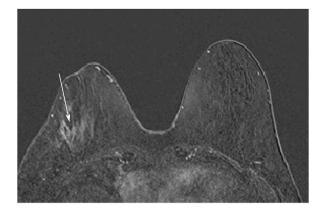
Axial subtraction image of bilateral breast MRI acquired at the end of neoadjuvant chemotherapy shows non-mass enhancement in the same region as in Fig. 4, indicating residual disease (arrow).
